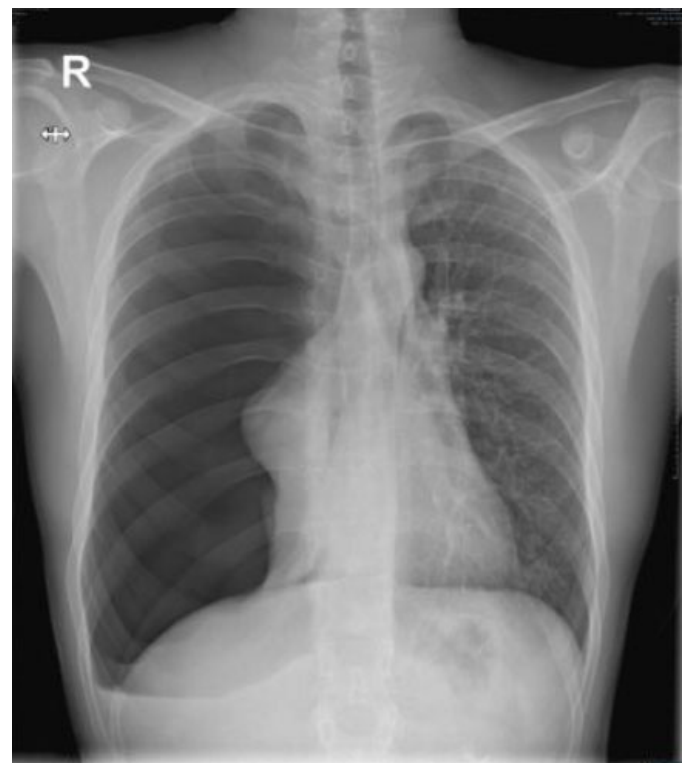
Chest X-ray done for the patient after the CT abdomen finding of the right sided large pneumothorax.
